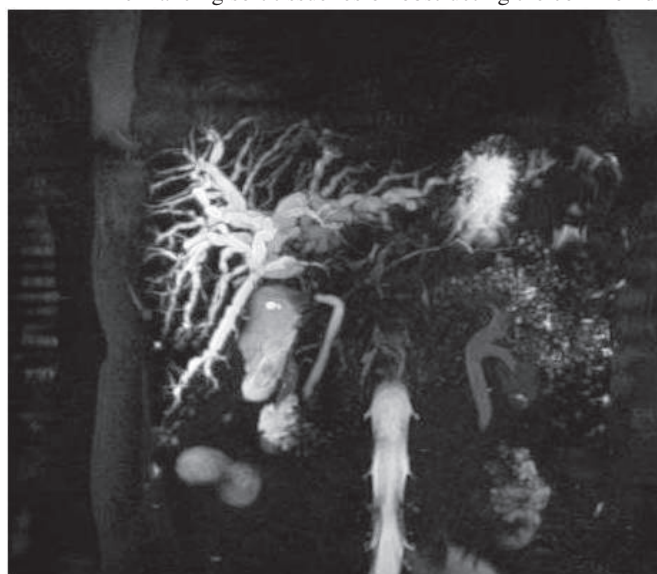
3D-MRCP confirms the CT findings of a short segment biliary stricture with upstream biliary dilatation. Remaining mid and distal common duct is unremarkable.
